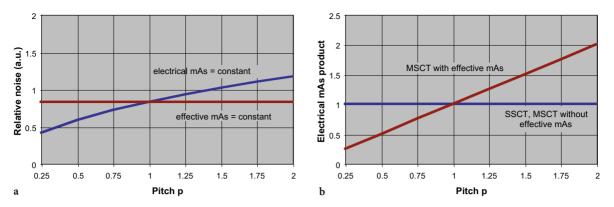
For multi-slice computed tomography (MSCT) systems that employ multi-point spiral data interpolation (z-filtering), image noise changes with pitch unless the effective current-time product (mAs_{eff}) is held constant (a). This implies that the electrical current-time product (mAs_{el}) supplied to the tube changes with pitch (b). Contrary to single-slice computed tomography (SSCT), changes in pitch settings therefore no longer have any influence on patient dose in terms of $CTDI_{vol}$
